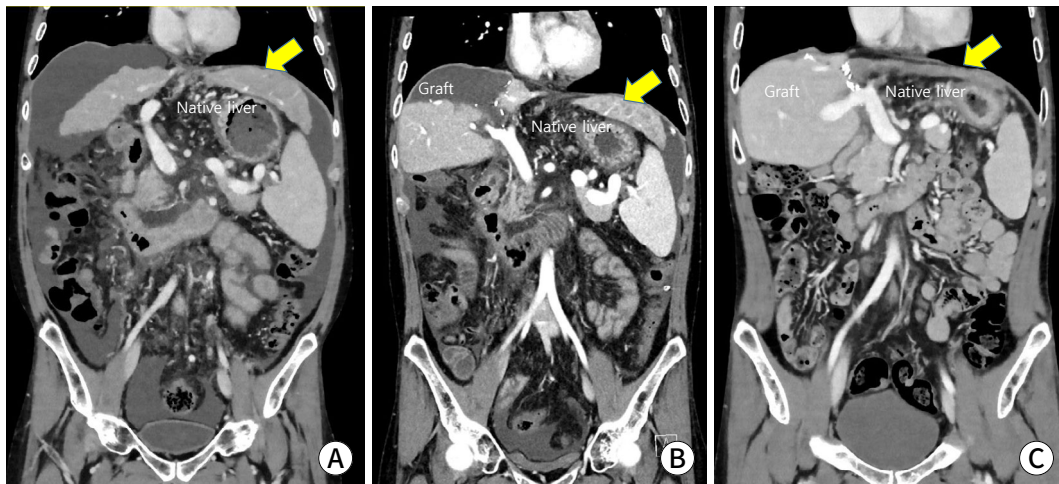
Auxiliary partial orthotopic liver transplantation to prevent the small-for-size syndrome. A 36-yr-old patient with Wilson's disease has undergone living-donor liver transplantation from a 54-yr-old mother using a right posterior section graft. The graft-versus-recipient weight ratio is 0.64%. He has undergone a native liver hepatectomy 11 mo after transplantation. (A) A preoperative recipient computed tomography (CT) scan. (B) A CT scan of postoperative day 9. (C) A CT scan of postoperative 11 mo.
